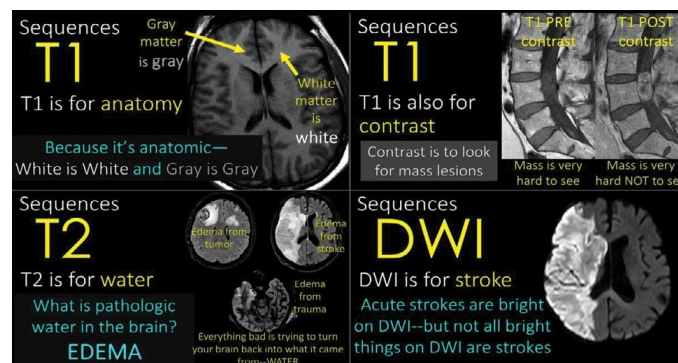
Represents magnetic resonance imaging (MRI) sequences.
